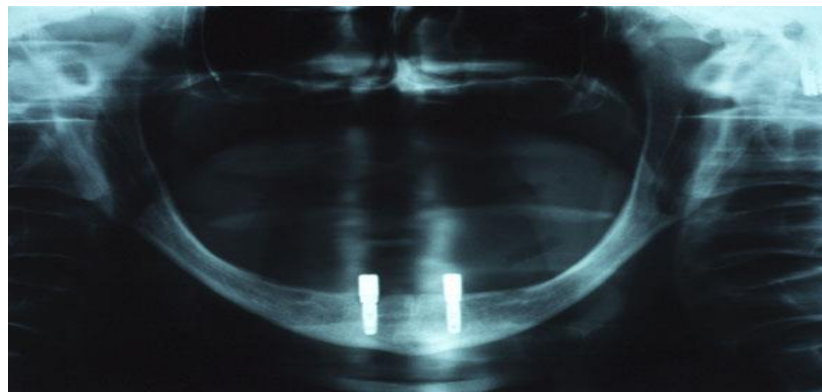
PANORAMIC RADIOGRAPHY
